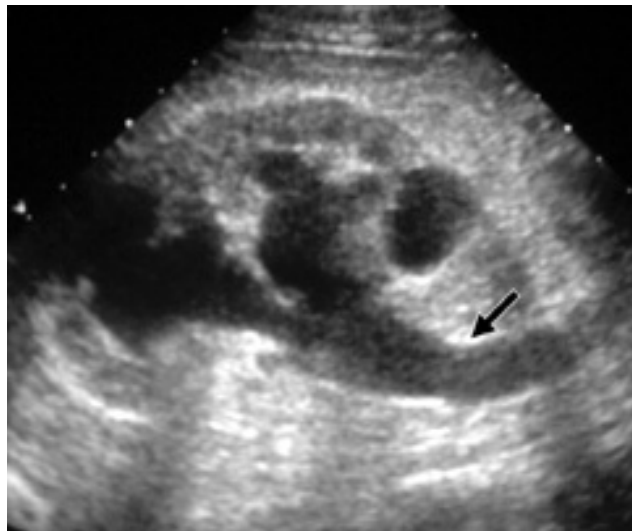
Longitudinal ultrasound image of the kidney, showing a moderate degree of hydronephrosis and hydroureter (arrow) [101]
